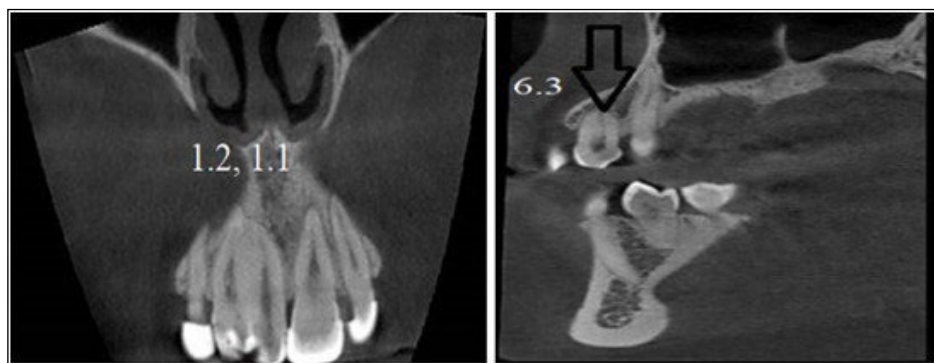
Patient K. 21 years old. CBCT at recall radiological examination. Coronal, sagittal slices. Tooth 2.3 displacement and rotation, 1.1, 1.2 teeth concretion, tooth 1.8 retention and dystopia, tooth 4.1
